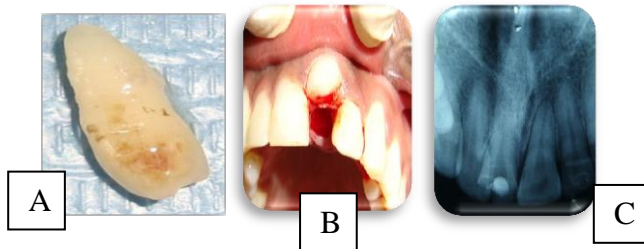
After extracted super numary tooth (A) the clinical area (B) on radiography view (C).
